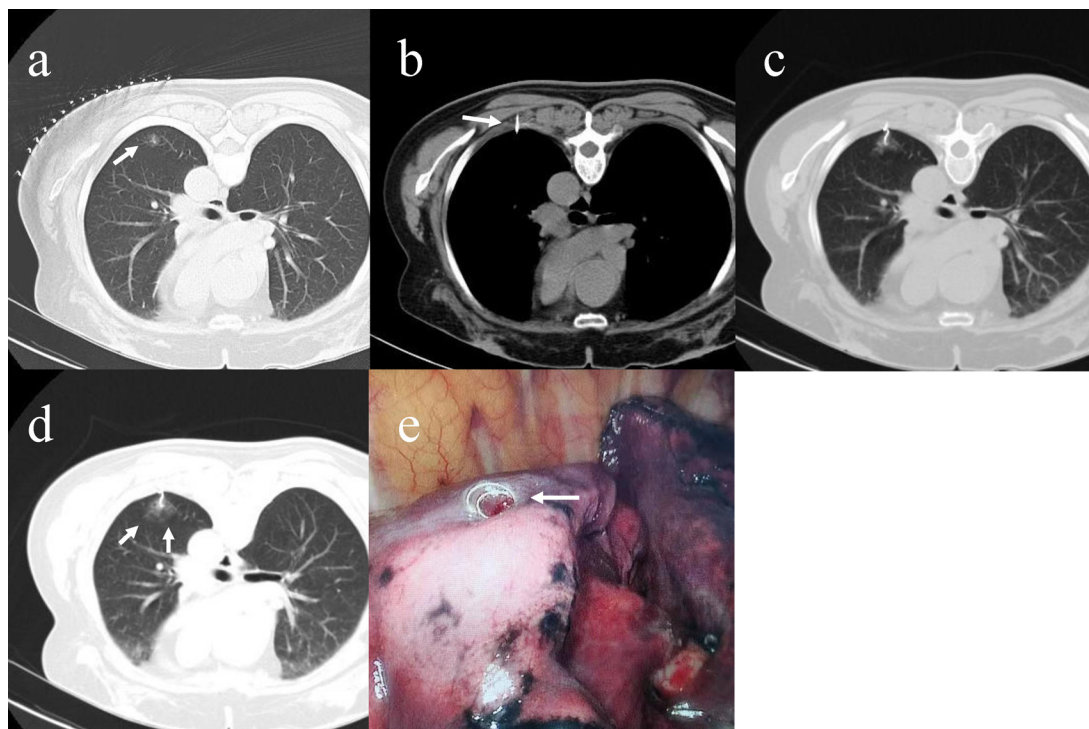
A 62-year-old male with a pulmonary nodule in the left lower lobe. (a) Axial CT image showing lesion (arrowhead) in the left lower lobe. (b) Needle tip (arrowhead) was advanced into the normal lung parenchyma to within 10 mm of the lesions. (c) The microcoil was released with the superficial end of the microcoil beyond the visceral pleura and the distal end coiled in the lung parenchyma adjacent to the nodule. (d) A repeat CT scan indicated a satisfactory localization, with new shadows (arrowhead) around the lesion suggestive of intrapulmonary hemorrhage. (e) The superficial end of the microcoil (arrowhead) was visualized using a thoracoscope to guide wedge resection. CT, computed tomography.
